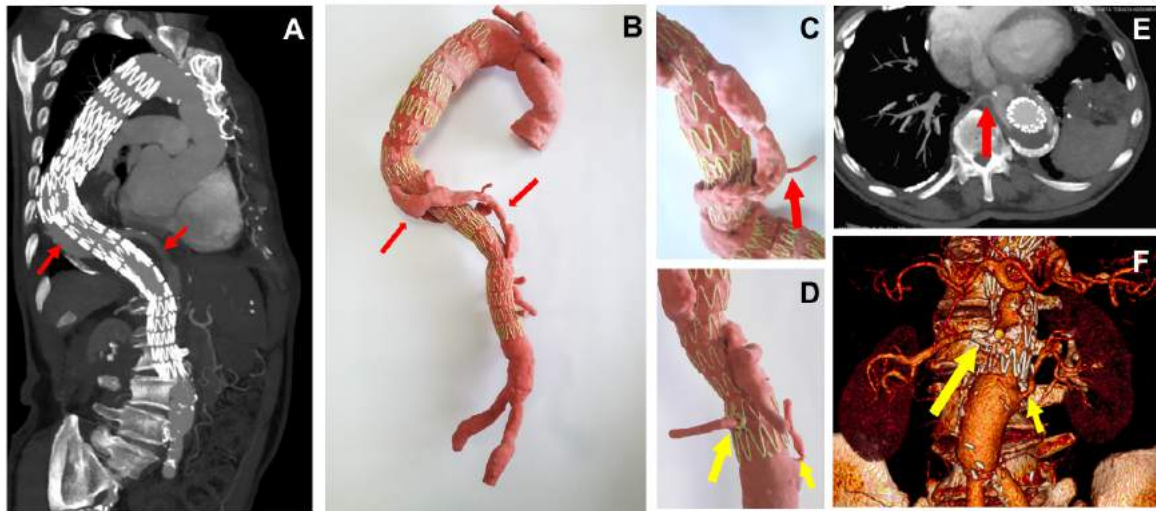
(A) CT scan and (B) the corresponding 3D model show the outcomes of the first stage of the planned two-stage totally endovascular treatment. As shown by the red arrows (A-B), intercostal branch flow was preserved to reduce the risk of paraplegia. (C) A detail of the 3D printed model showing the preserved intercostal artery, as also depicted in (E). Yellow arrows in (D) and (F) highlight patency of the descending aorta secondary branches.
